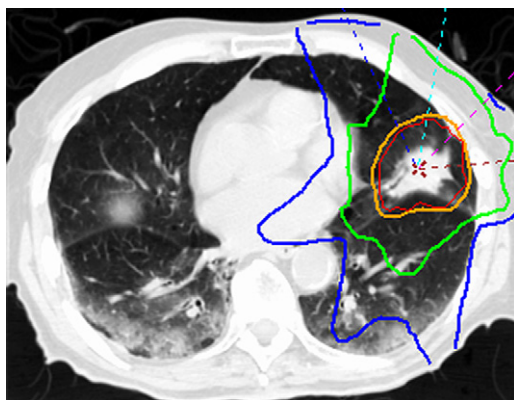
Example of radiation plan created using intensity-modulated radiotherapy (IMRT) in a patient who presented with a peripheral lung mass contoured on a CT treatment-planning scan. With IMRT, a concave dose distribution can be accomplished to deliver prescription dose to the tumor volume while protecting normal structures, including surrounding normal lung. The surrounding multicolored lines represent isodose distributions. Each color represents a percentage of the prescribed dose received by the given volume encompassed within the curve. Precision in target volume delineation is essential when the radiation dose is prescribed with highly conformal techniques.
